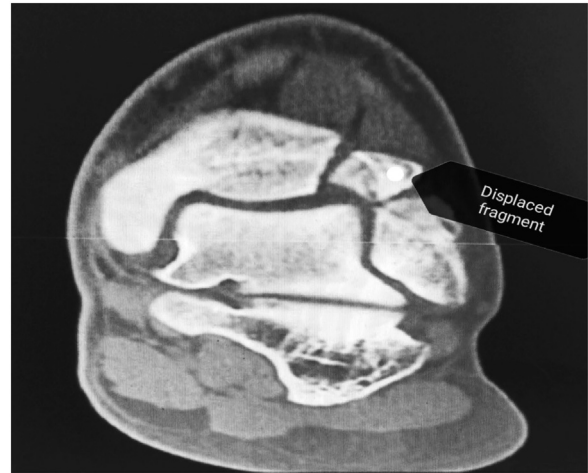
Pre-operative coronal CT scan of ankle joint showing displaced Tillaux fragment.
